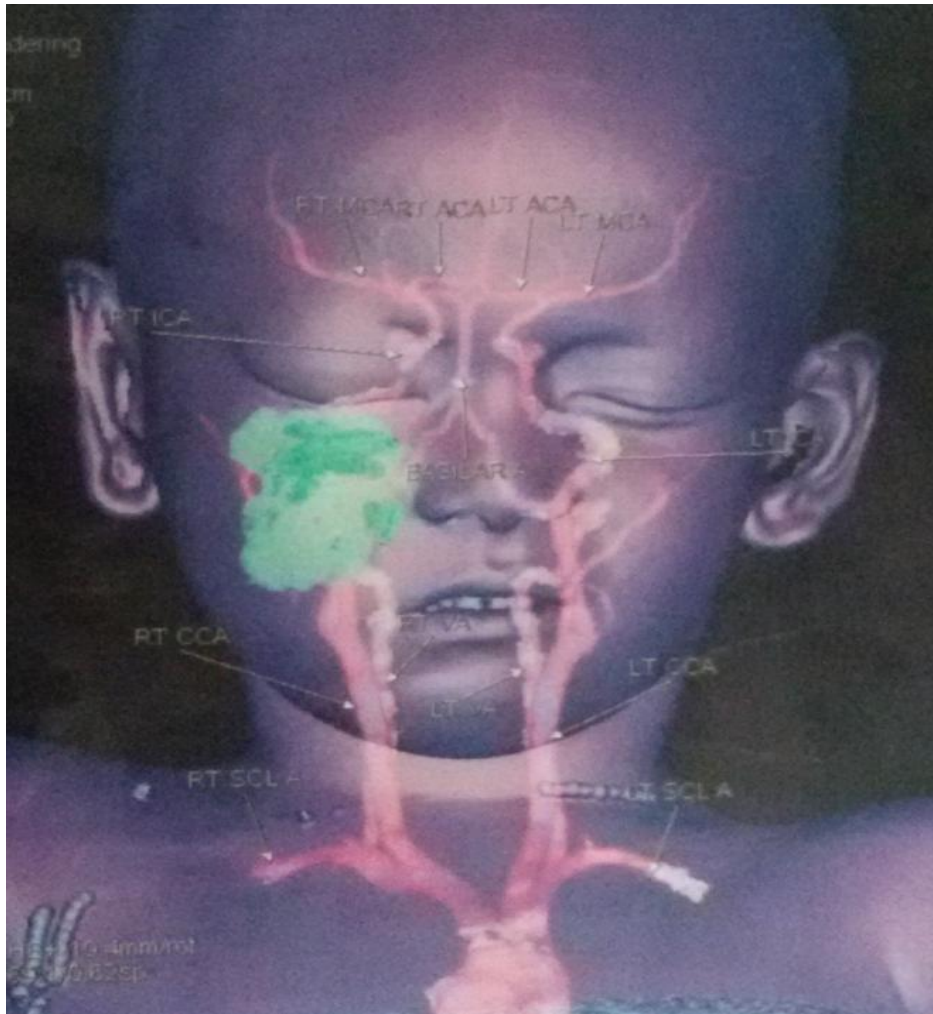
128 slice CT angiogram showing tortuous attenuating structures in the right orbit – suggestive of low flow vascular malformation
